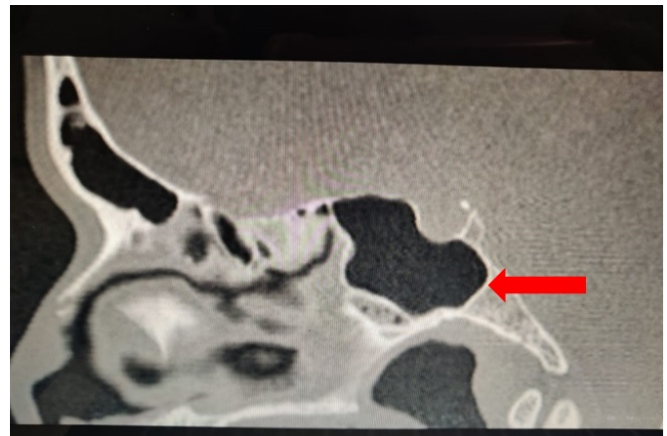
CT scan of PNS - Sagittal section showing Post-Sellar type of Sphenoid sinus pneumatization.
